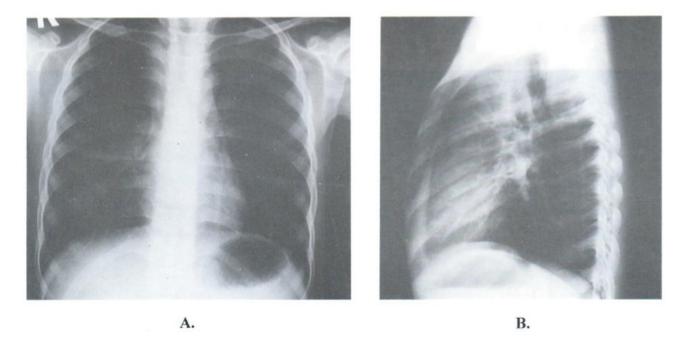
An 8 year old girl presented with fever and cough for 1 month. PA and lateral chest radiographs show right para-tracheal and right hilar adenopaty.
